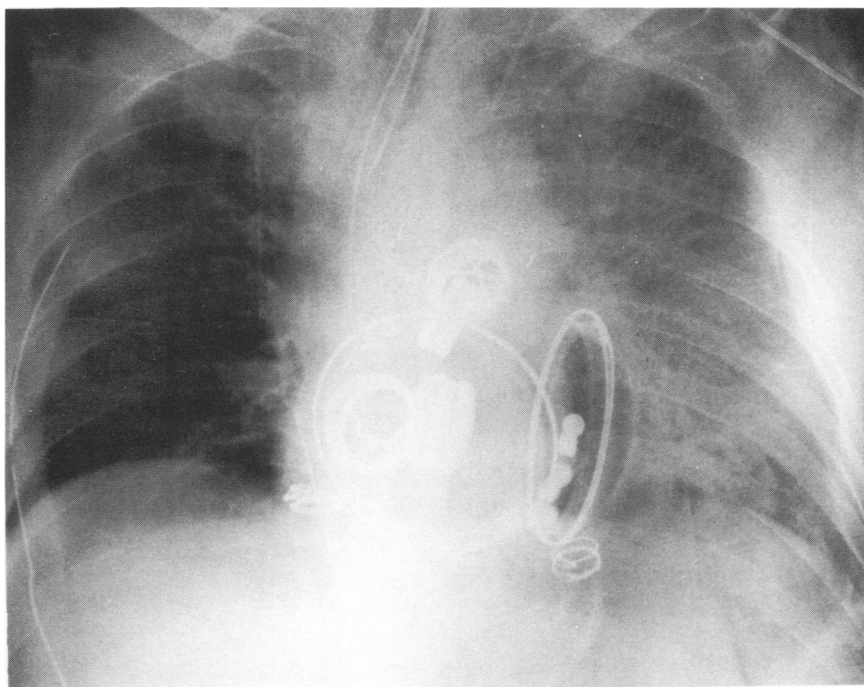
Roentgenogram of the chest showing the total artificial heart in situ 6 hours after implantation. Note that the lungs are clear.
